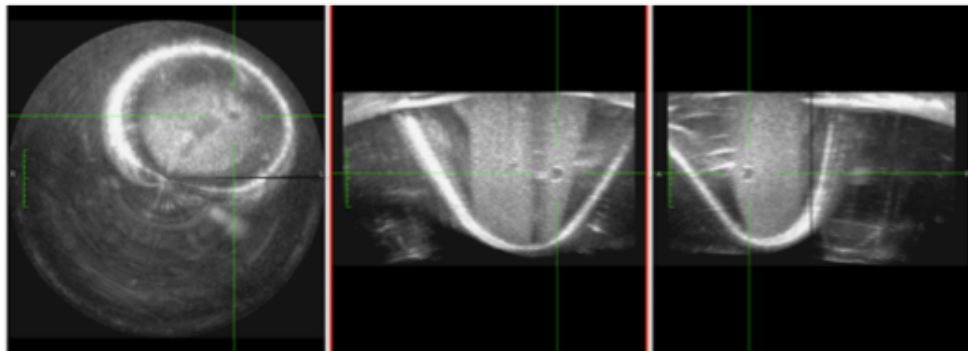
Three plane arrangement of the 3D ultrasound matrix data represented in DICOM.
